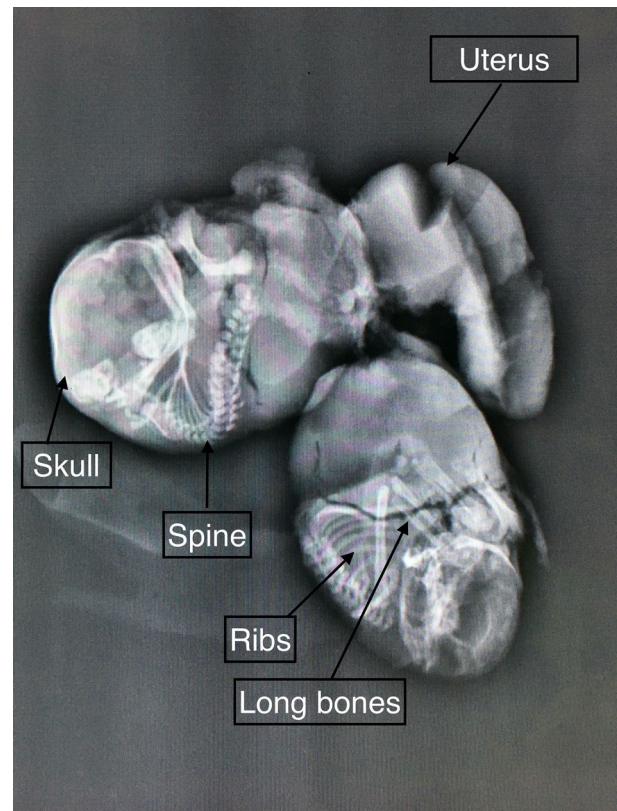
Plain X-ray showing fetal skull, well-formed spine, ribs, and long bones
